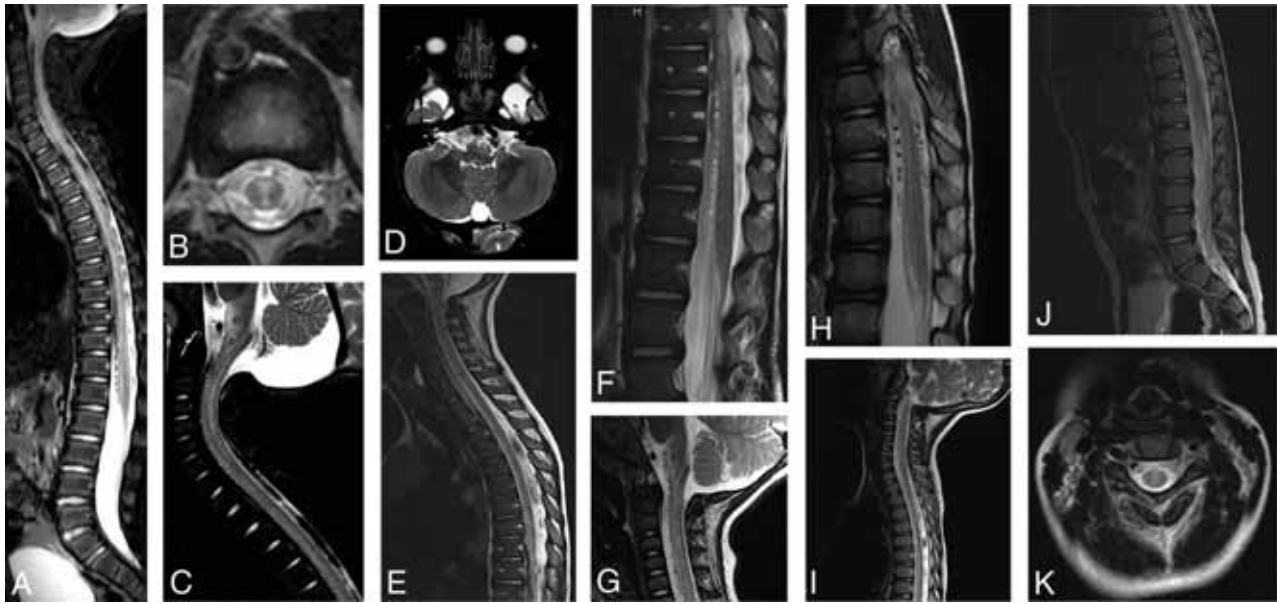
Spine MR imaging findings. *A*, Midline T2-weighted sagittal MR image of the spine in patient 1 shows abnormal T2-weighted hyperintense signal in the thoracic spinal cord and conus medullaris. Spinal cord volume expansion is also present. There is conspicuous abnormal perimedullary vascular ectasia anterior to the conus medullaris and thoracic spinal cord. *B*, Axial T2-weighted image of the midthoracic spine shows the distribution of abnormal T2-weighted signal hyperintensity within the central and anterior spinal cord. *C*, Midline T2-weighted sagittal MR image of the cervical spine reveals abnormal T2-weighted hyperintense signal in the central cervical spinal cord and ventral medulla. There is diffuse spinal cord swelling affecting the region of the cervical enlargement. *D*, Axial T2-weighted image of the brain at the level of the medulla shows T2-signal hyperintensity in the pyramids, more conspicuous on the left. *E*, Midline T2-weighted sagittal MR image of the cervical and thoracic spine in patient 4 shows abnormal T2-weighted hyperintense signal in the ventral cervical and thoracic spinal cord and medulla. There is spinal cord volume expansion, prominent in the region of the cervical enlargement, and abnormal perimedullary vascular ectasia anterior to the thoracic spinal cord. *F*, Midline T2-weighted sagittal MR image of the lower thoracic and lumbar spine reveals abnormal T2-weighted hyperintense signal in the anterior spinal cord. There is diffuse spinal cord swelling, severely affecting the region of the lumbar enlargement. Note marked ectasia of the perimedullary vessels anterior to the spinal cord. *G*, Midline T2-weighted sagittal MR image of the cervical spine in patient 3 shows abnormal T2-weighted hyperintense signal in the central and anterior cervical spinal cord as well as in the ventral medulla. Mild expansion of cervical spinal cord volume is also present. Conspicuous abnormal perimedullary vascular ectasia anterior to the cervical spinal cord is demonstrated. *H*, Midline T2-weighted sagittal MR image of the lower thoracic spine reveals abnormal T2-weighted hyperintense signal in the central and anterior thoracic spinal cord and conus medullaris, with mild associated volume expansion. Note marked perimedullary vascular ectasia surrounding the spinal cord. *I*, Midline T2-weighted sagittal MR image of the cervical and thoracic spine in patient 2 shows abnormal T2-weighted hyperintense signal in the cervical and thoracic spinal cord. The region of the cervical enlargement is severely affected and shows mild volume expansion. *J*, Midline T2-weighted sagittal image of the lower thoracic and lumbar spine shows abnormal T2-weighted signal hyperintensity within the anterior spinal cord. There is conspicuous perimedullary vascular ectasia anterior to the conus medullaris. *K*, Axial T2-weighted MR image of the cervical spine reveals abnormal T2-weighted hyperintense signal in the central cervical spinal cord.
